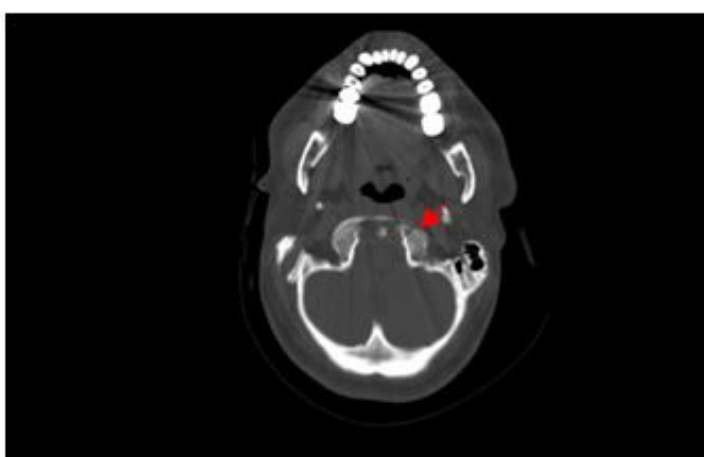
Non contrast head CT (axial view) showing A left sided occipital condyle fracture.
